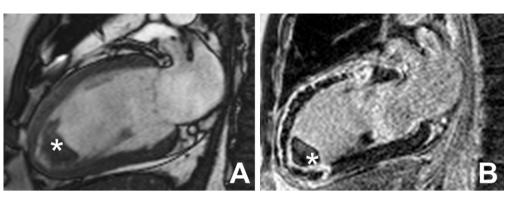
Left ventricular thrombus formation on late gadolinium enhancement cardiac magnetic resonance imaging. (A) Cine cardiovascular magnetic resonance of a thrombus (asterisk) in the apex of the left ventricle. (B) Late gadolinium enhancement imaging neatly confirms the avascular non-enhancing thrombus (asterisk) close to the transmural infarcted myocardium with areas of microvascular obstruction. LV, left ventricular.
